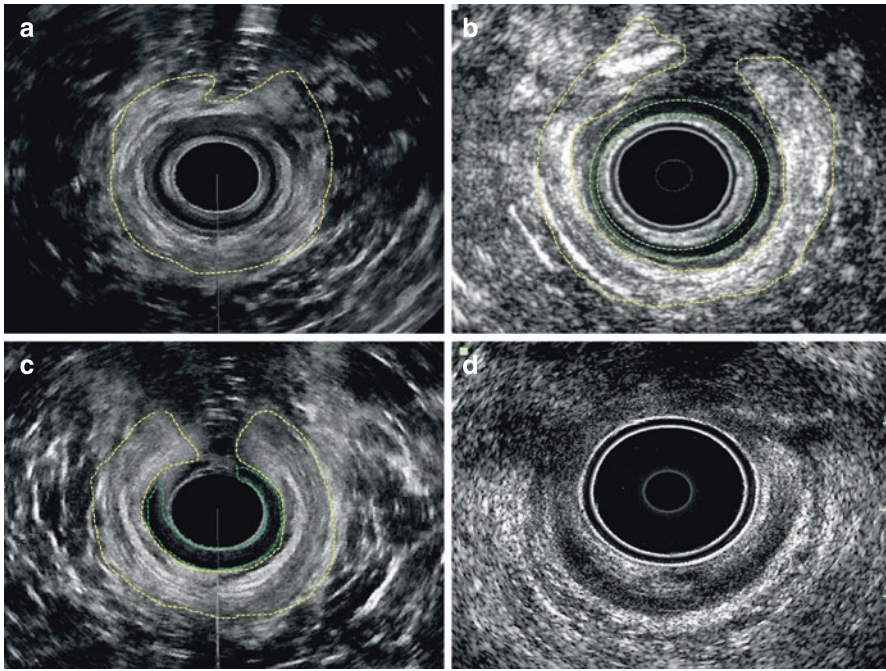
Different grades of obstetric anal sphincter injuries (OASIS) on endoanal ultrasonography: (a) OASIS grade 3a; (b) OASIS grade 3b; (c) OASIS grade 3c; (d) OASIS grade 4
